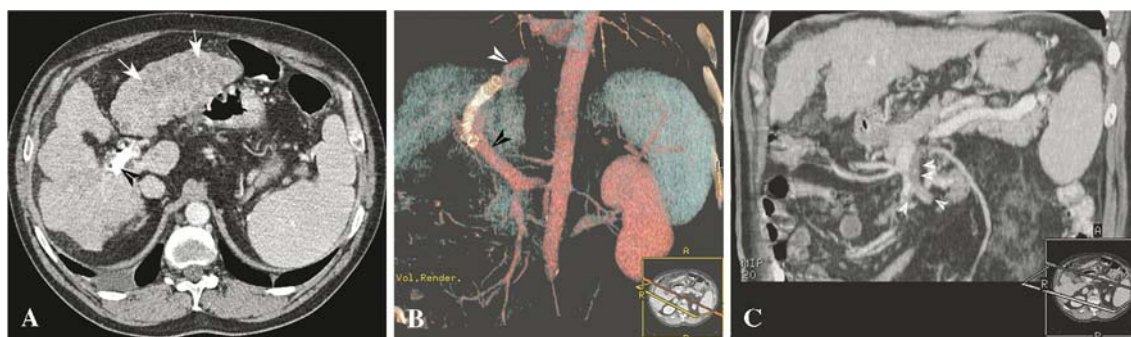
(A) CT after TIPSS revision showed that the TIPSS tract is perfused (black arrowhead); the liver is cirrhotic, and in the venous phase slightly inhomogeneous (white arrows). (B) The three-dimensional volume-rendered reconstruction showed a standard location
